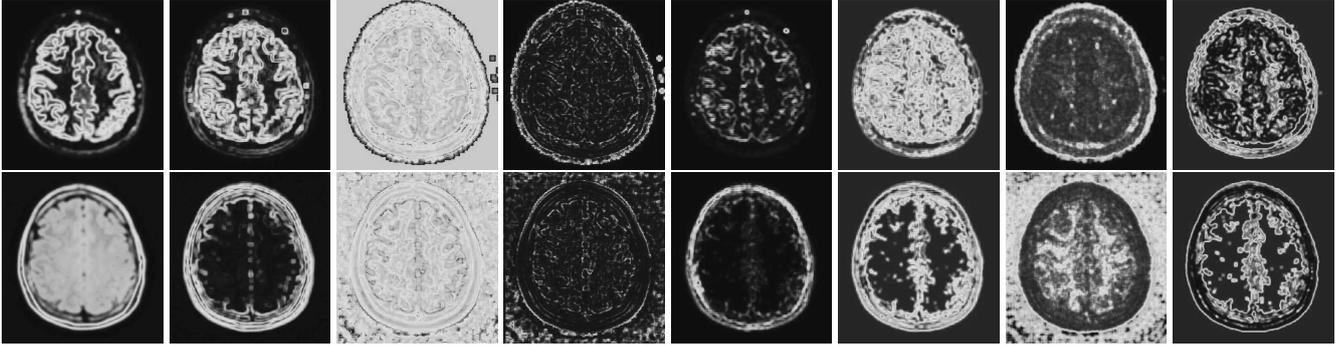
Upper row*: 8 textures extracted from the DIR slice. *Lower row*: 8 textures extracted from the FLAIR slice. *Columns, from left to right*: mean, standard deviation, skewness, kurtosis, contrast, homogeneity, entropy, energy. The scale employed is 5 (5×5 pixel block analysis). Original DIR and FLAIR slices are the one in Fig. 1; the slice is at $z = 33$.
